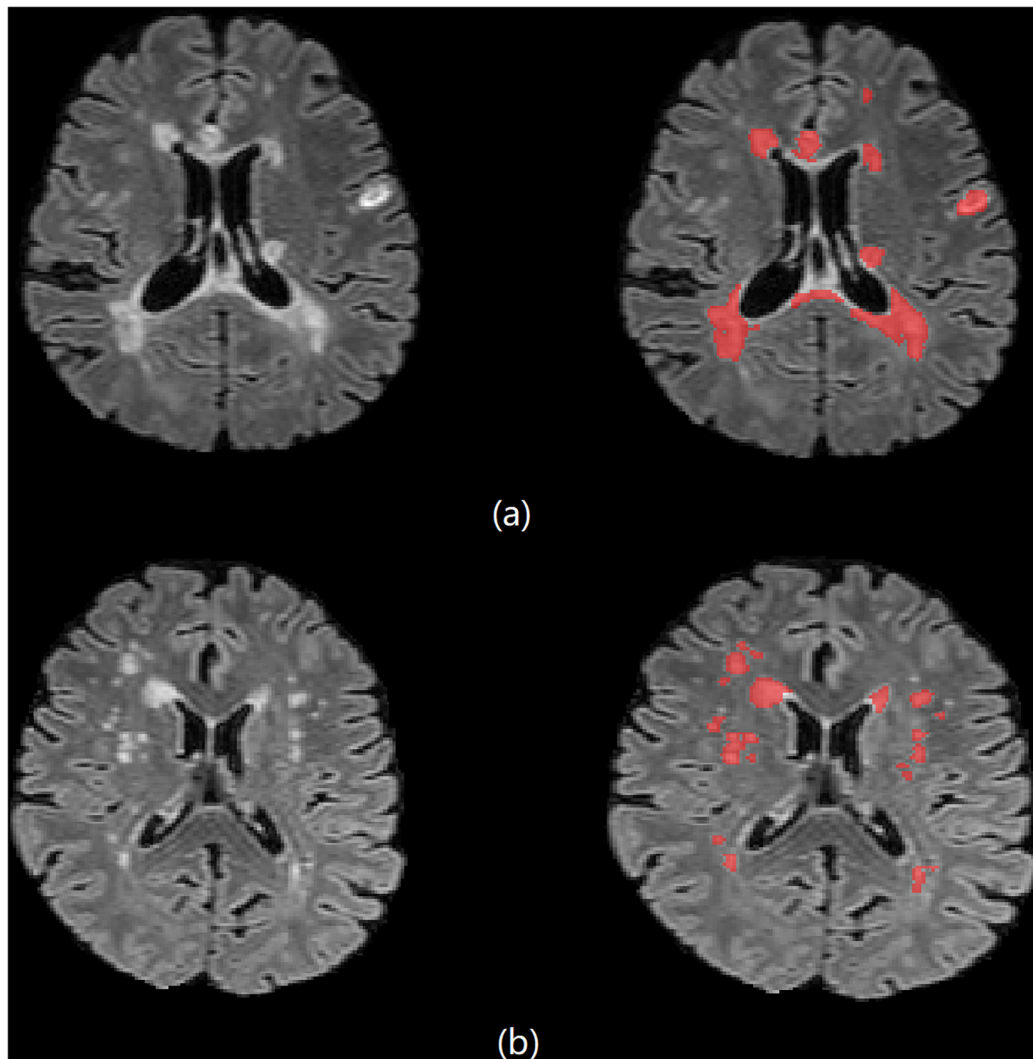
Brain 3D T2-FLAIR MR images of (a) one 33-year-old female MS patient and (b) one 61-year-old female NMOSD patient.
